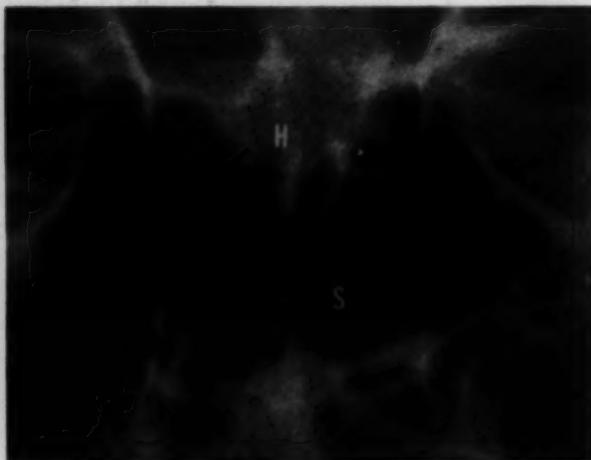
(Kirk). Anteroposterior X-ray film, showing the injected lipiodol in the canaliculus and sac.
